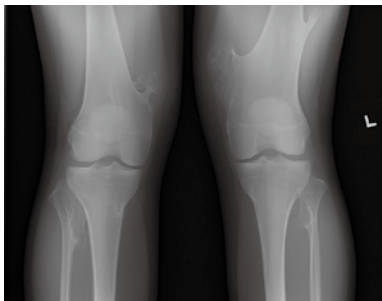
X-ray bilateral knees (frontal views)
